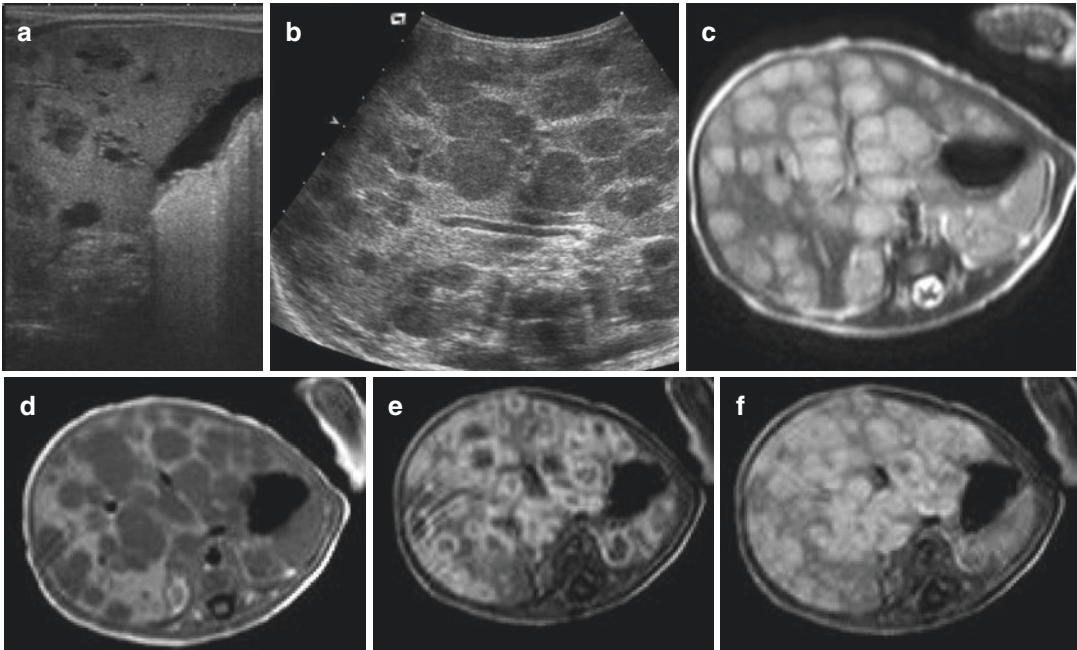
Neonatal multiple liver hemangiomas: various aspects on US and typical MRI patterns. (a) In one infant, well delimited multiple hypoechoic nodules with peripheral hyperechoic rim. (b) In another infant with multiple hepatic hemangiomas: On US, multiple well-delimited hypoechoic nodules. (c) Multiple nodules with high signal
